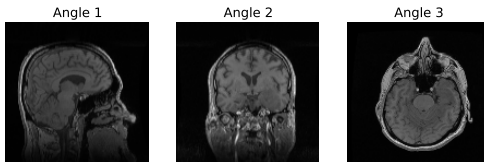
FIGURE – Viewing angles of MRI scan
